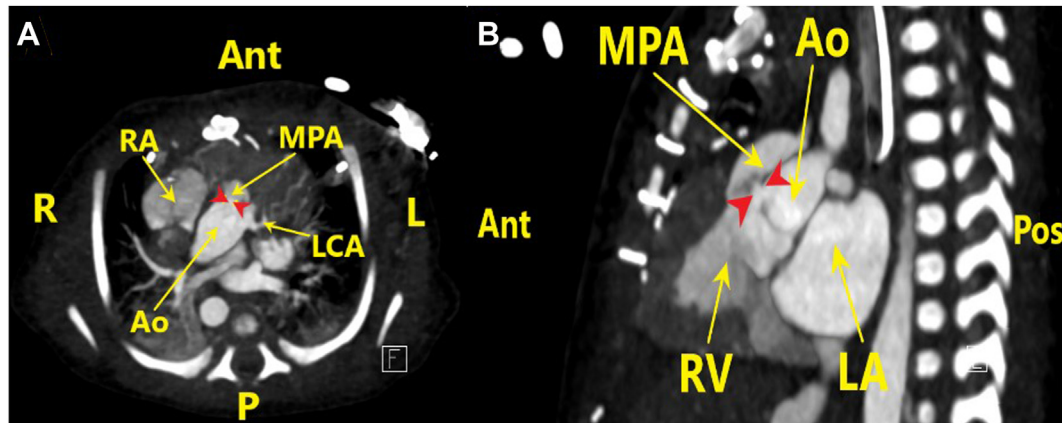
Cardiac computed tomography angiogram. Axial source image (A) and sagittal oblique multiplanar reformat (B) image showing the small APW (red arrows) between the aortic root posteriorly and the proximal, hypoplastic MPA anteriorly. *Ant*, Anterior; *Ao*, aorta; *L*, left; *LA*, left atrium; *LCA*, left coronary artery; *MPA*, main pulmonary artery; *P*, Pos; *RA*, right atrium; *R*, right; *RV*, right ventricle.
